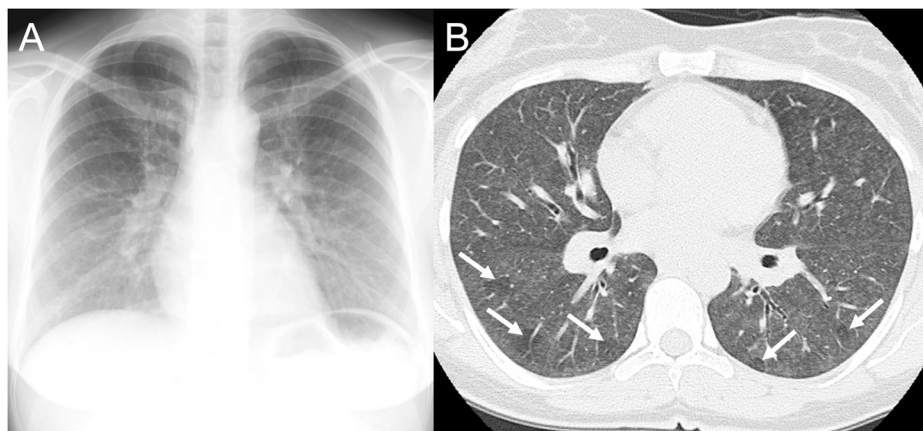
Panel A: Chest radiograph revealed mild infiltrate predominantly in the middle to lower lobes of both lungs. Panel B: HRCT scan revealed ground-glass opacities with numerous poorly defined centrilobular nodules and some lobular areas of decreased attenuation (arrows) throughout both lungs.
